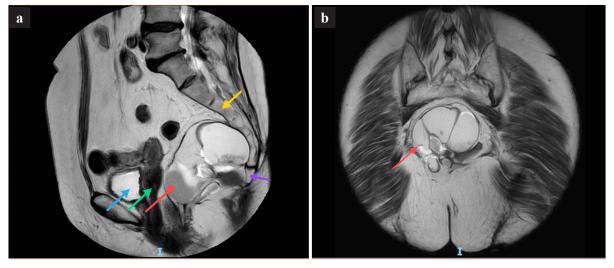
MRI a – T2WI sagittal position: The mass (red arrow) extends from the third sacral vertebra (yellow arrow) to the coccyx (purple arrow). Surrounding anatomical structures include the rectum (green arrow) and the bladder (blue arrow). b – T2W-TSE (Turbo Spin Echo) coronal position: The mass appears multilocular (red arrow).
